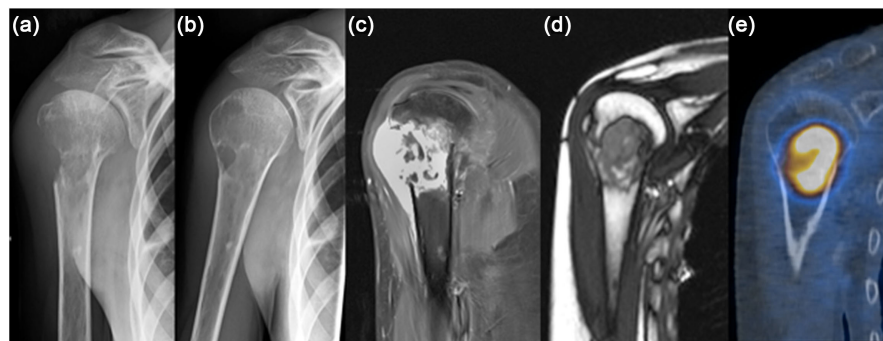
Radiation induced osteosarcoma proximal humerus 11 years after treatment of Ewing sarcoma of the scapula. X-Ray (a, b) showing the osteolysis, MRI t1 fs (c) and t2 trufl (d) the expansion of the osteosarcoma, FDG-PET-CT (e) the intensive uptake.
